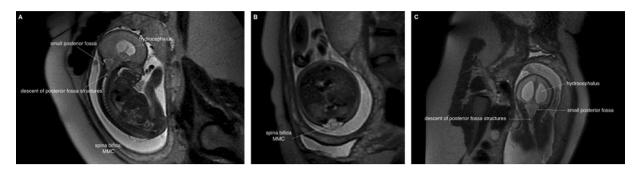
A. Fetal MRI, SSFSET2 sequence, sagittal plane: Chiari II — descent of the posterior fossa structures into cervical vertebral canal, small posterior fossa, supratentorial hydrocephalus, spin bifida cum myelomeningocele (arrows); B. Fetal MRI, SSFSET2 sequence, axial plane: Chiari II — spina bifida, myelomeningocele (arrows); C. Fetal MRI, SSFSET2 sequence, coronal plane: Chiari II — descent of the posterior fossa structures into cervical vertebral canal, small posterior fossa, supratentorial hydrocephalus, spin bifida cum myelomeningocele (arrows); B. Fetal MRI, SSFSET2 sequence, axial plane: Chiari II — descent of the posterior fossa structures into cervical vertebral canal, small posterior fossa, supratentorial hydrocephalus (arrows)
